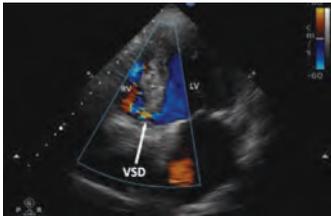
Transthoracic apical 4 chamber view showing left to right shunt at interventricular septum level. VSD=Ventricular Septal Defect, RV= Right Ventricle, LV=Left Ventricle.
